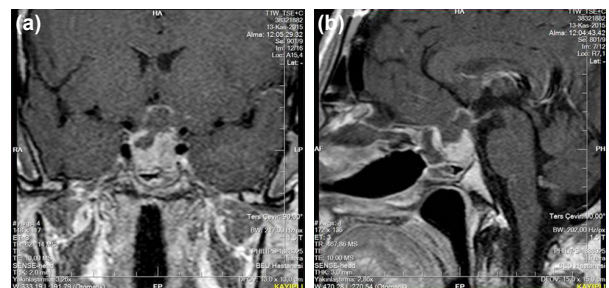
The tumor's suprasellar part has been evacuated and the optic chiasm compression eliminated at the 3-month control, after a pterional craniotomy. (a) Coronal T1 C+ magnetic resonance imaging (MRI). (b) Sagittal T1 C+ MRI.
